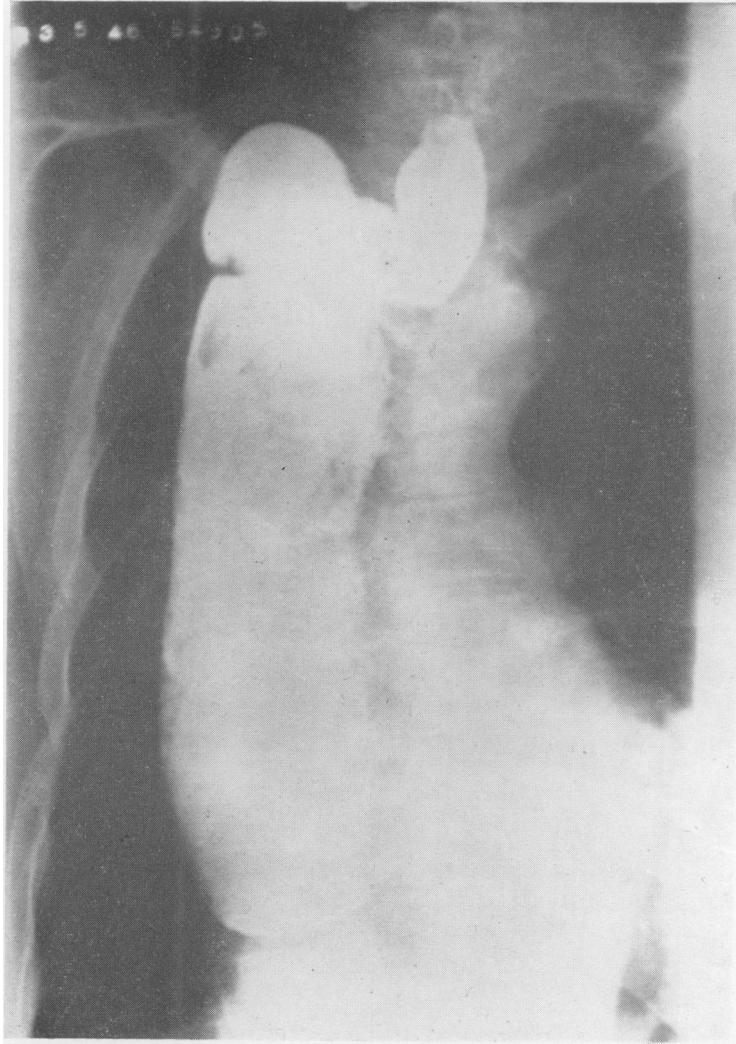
X-ray of barium swallow, after author's method of oesophagectomy showing anastomosis at level of sternoclavicular joint.
